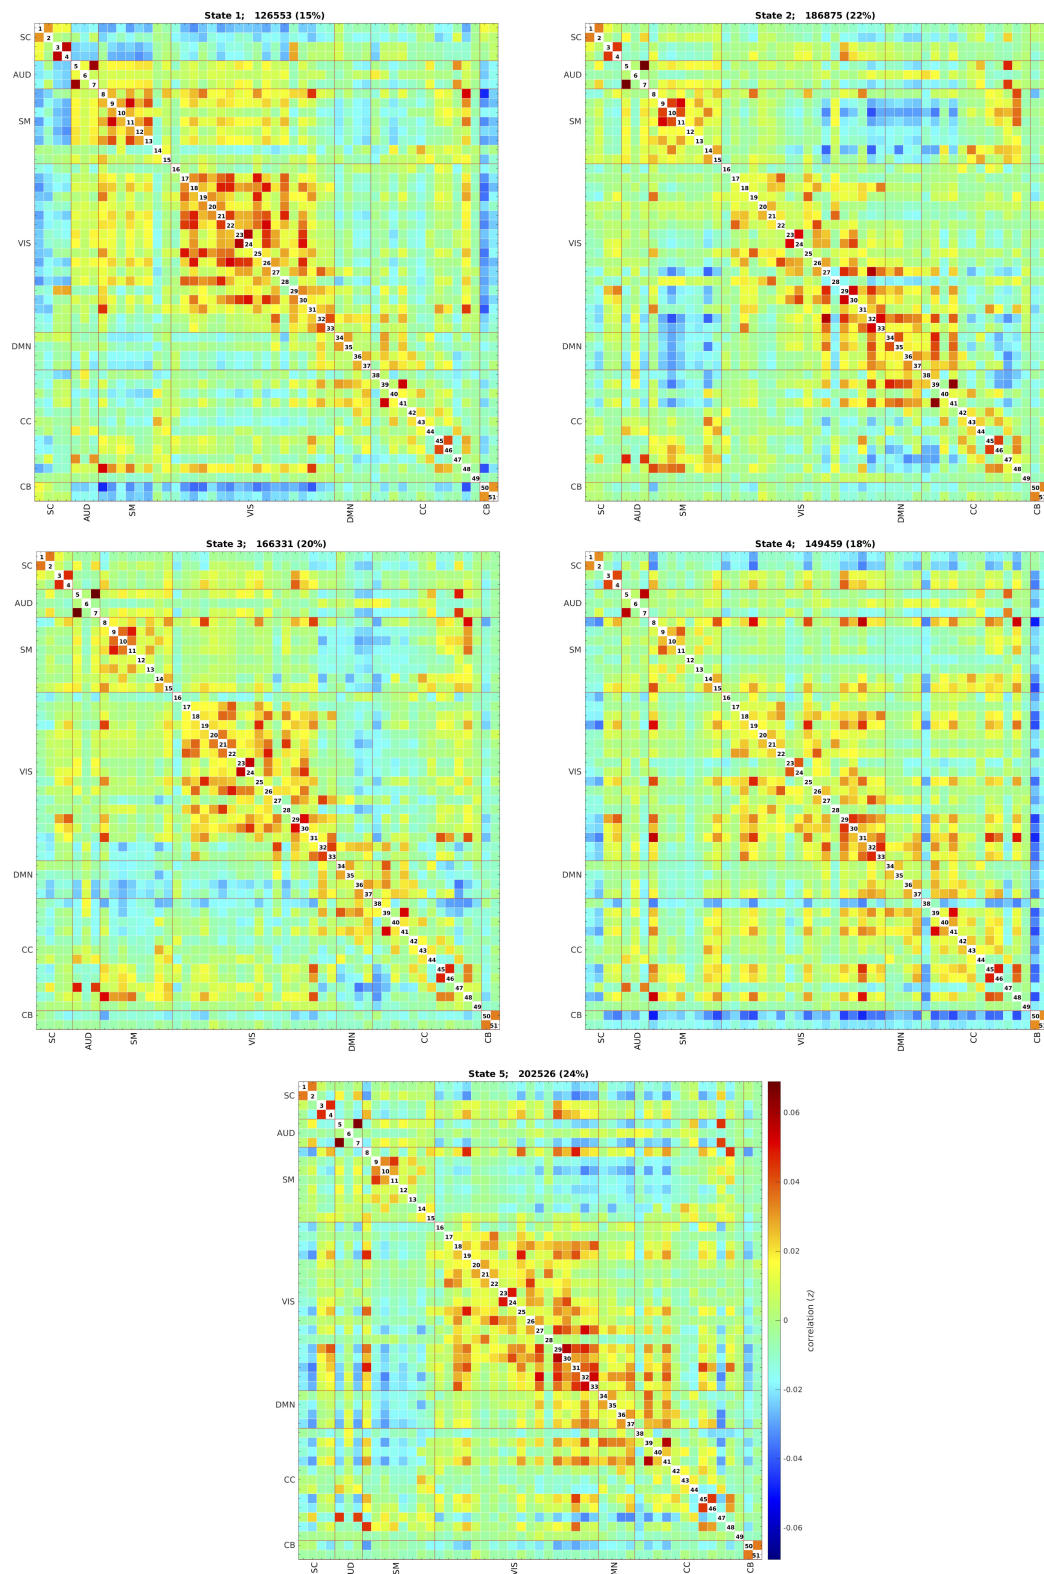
Five dynamic states after clustering across all individuals and visits. Each state captures a particular connectivity ‘configuration’ a participant may display over the course of the MRI scan. The total number and percentage of occurrences (windows of time) is listed above each state. SC, subcortical network; AUD, auditory network; SM, sensorimotor network; VIS, visual network; DMN, default-mode network; CC, cognitive control network; CB, cerebellar network.
